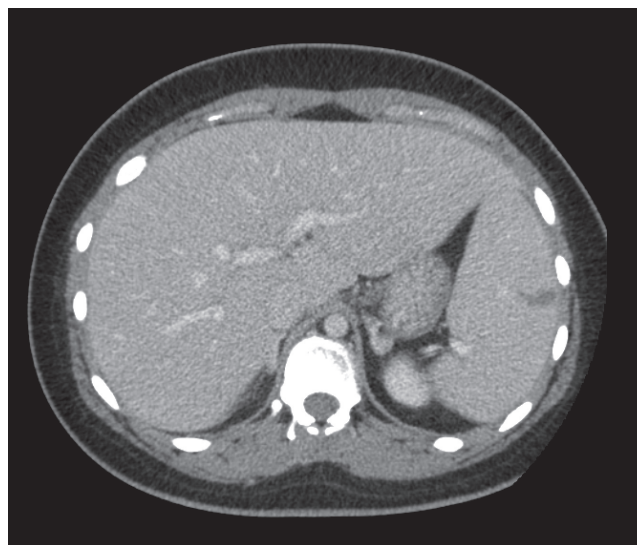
Computed tomography scan showing the splenic infarct.
